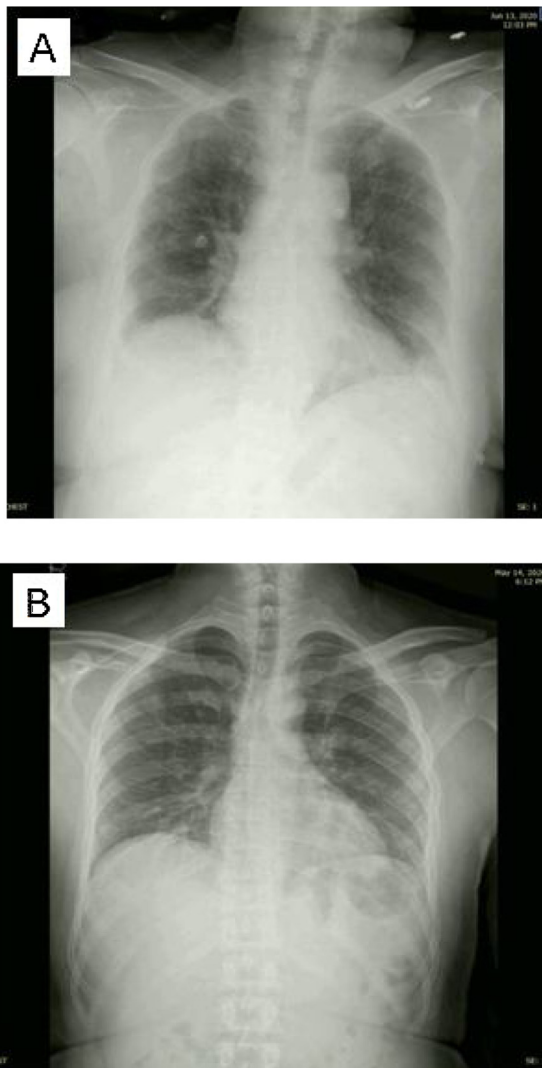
(A) Case 1, chest X-ray depicting bilateral coarse reticular shadow with no pleural effusion. (B) Case 2, chest x-ray depicting bilateral hilar bronchial wall thickening and no lung opacity.
